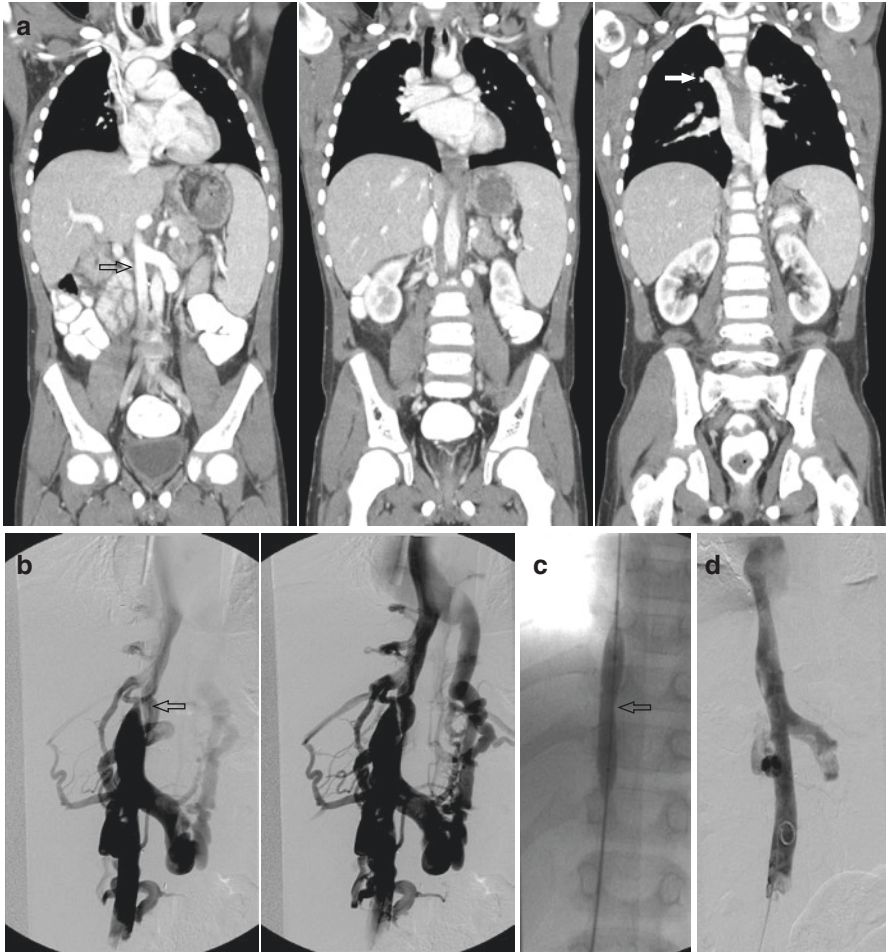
IVC stenosis: (a) CT venogram demonstrates a high-grade stenosis of the intrahepatic IVC. (b) Conventional venacavagram demonstrates complete occlusion of the IVC and development of extensive collateral veins. (c) Venoplasty of the stenotic segment. (d) Post-venoplasty image demonstrates no residual stenosis or collateral venous flow
